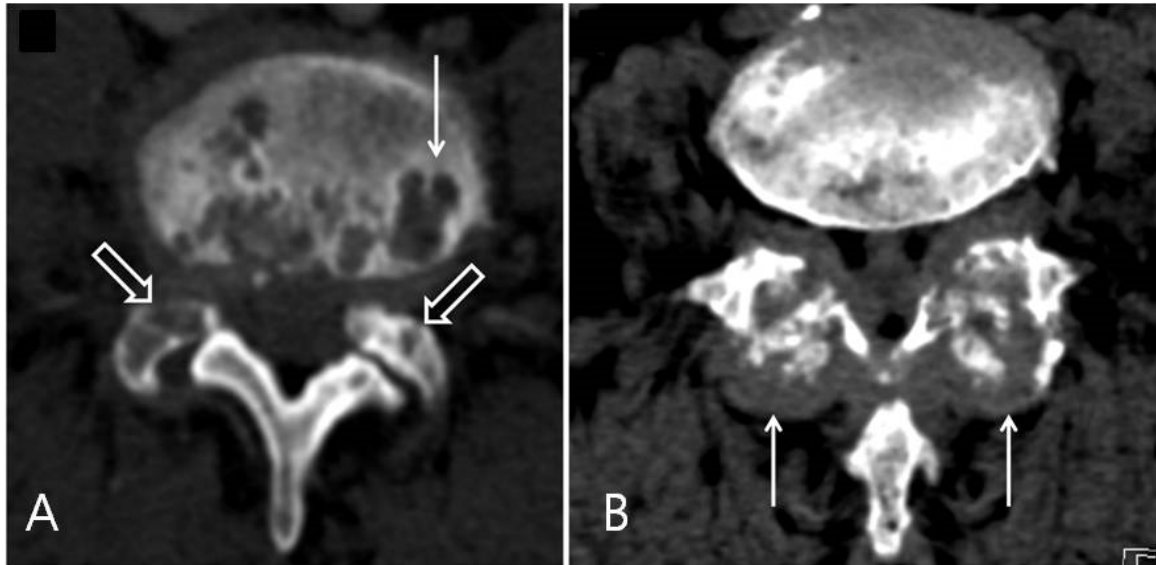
CT evidence suggestive of axial gout. (A) Erosive change with sclerotic margins in vertebral body or facet joints (white hollow arrows). (B) Tophi in facet joints
